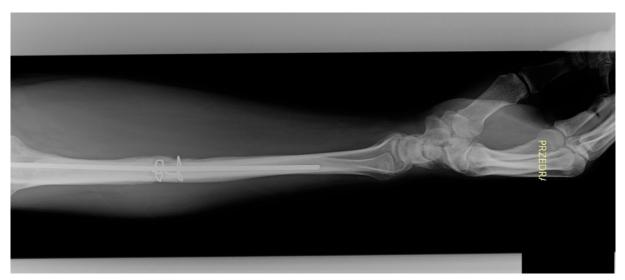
Lateral radiograph of the right forearm (eight months after surgery). Nonunion of right ulna.
